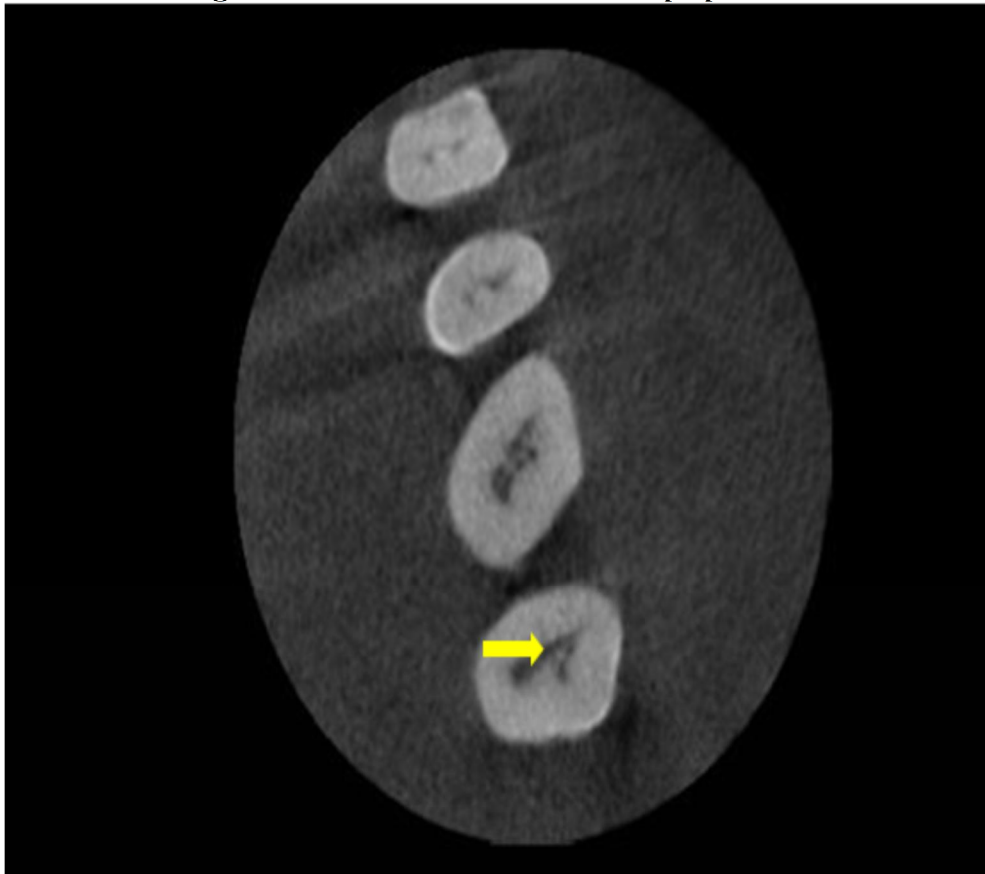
Axial section of CBCT with pulp stones
